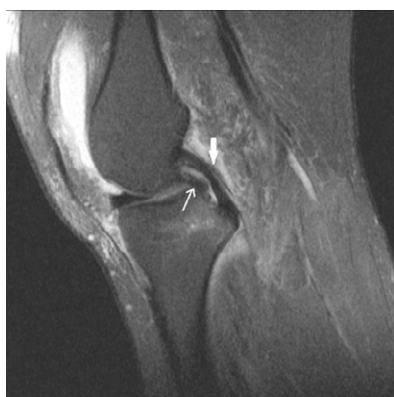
Sagittal T2-weighted MR image through the inter-condylar notch shows the double-posterior cruciate ligament (PCL) sign, which is characterized by the presence of a the displaced bucket-handle fragment of the medial meniscus (thin white arrow) lying parallel and anterior to the PCL (thick white arrow). Moderate joint effusion due to hemarthrosis is noted.
